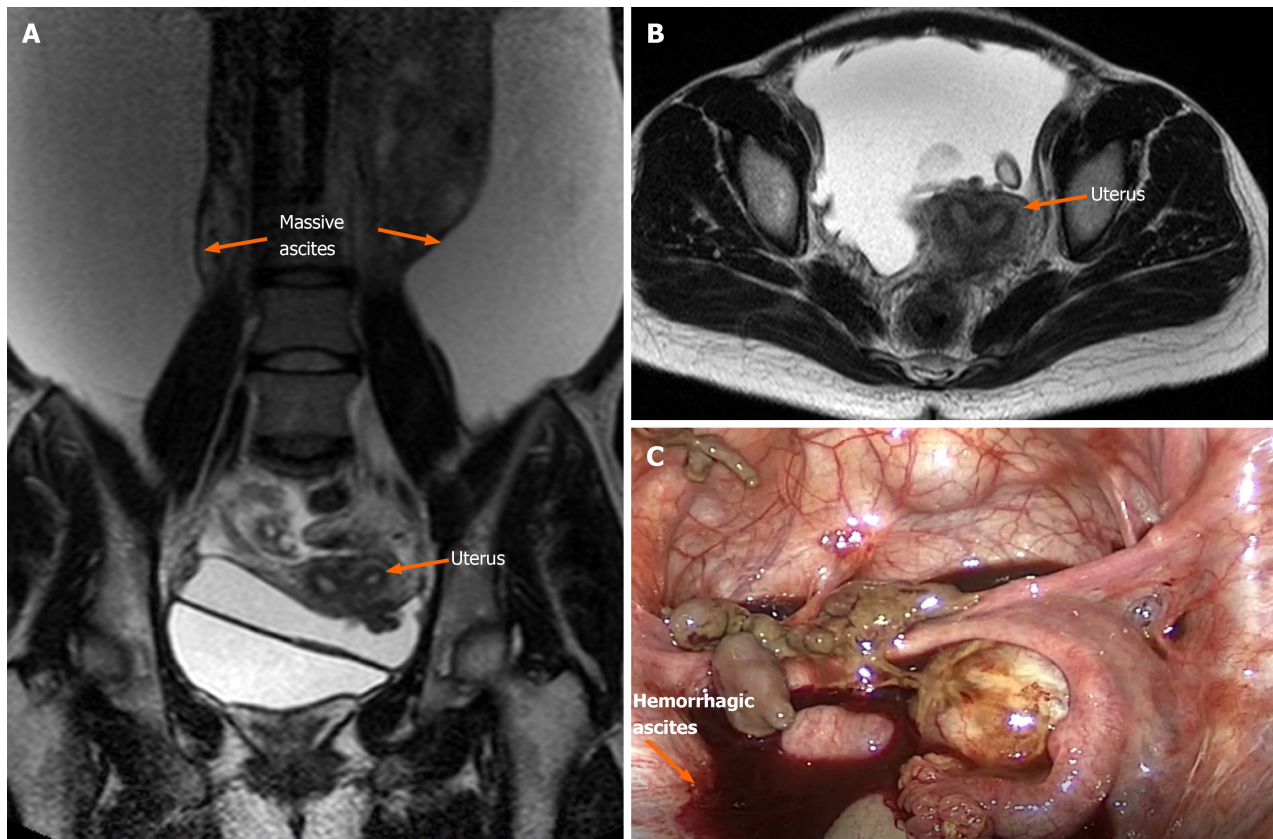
Bilateral ovaries were adhered to the posterior of the uterus, and endometriotic cysts were not observed in either ovary. A and B: Magnetic resonance imaging revealed a large amount of ascites, and slight invagination of the fundus uteri, which proceeded to combine with bicornuate uterus; C: Large amount of brown ascites and coagulated blood were observed in the pelvic cavity.
